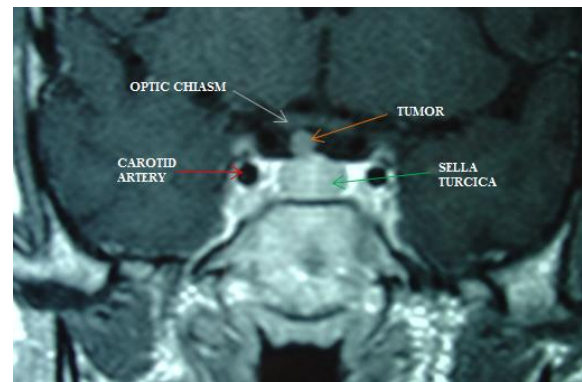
Nuclear magnetic resonance imaging showing a suprasellar ectopic tumor and adjacent structures (coronal section). After confirming the diagnosis of Cushing disease due to a suprasellar tumor adhered to the pituitary stalk, the surgical management was chosen and a craniotomy for tumor resection was performed.
